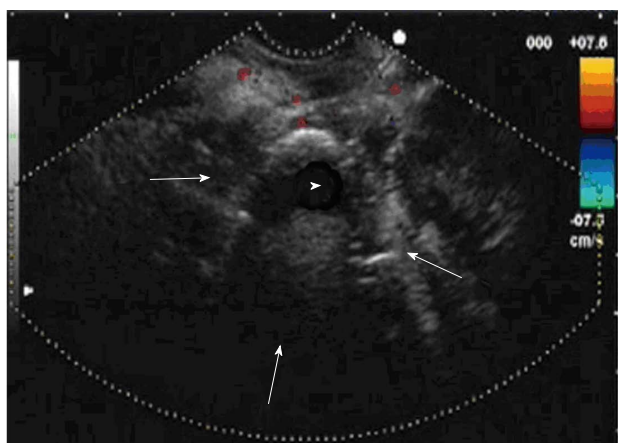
Endoscopic ultrasonography image of walled-off necrosis collection. The limits of the walled-off necrosis are signalled by the arrows. The necrotic content is marked with arrowhead.
